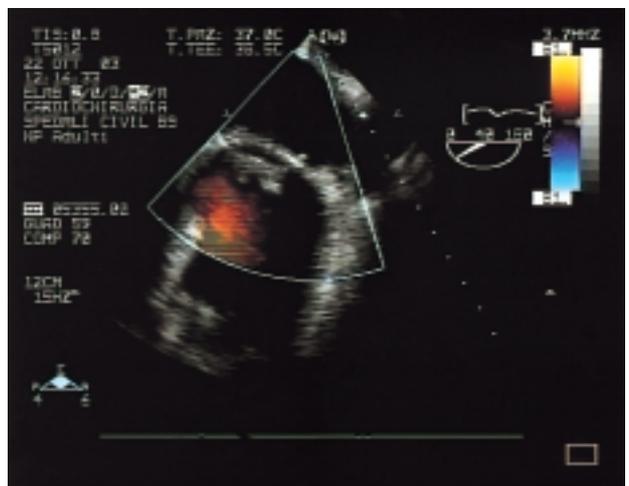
Preoperative transesophageal long-axis view of the prolapsing mitral valve; three regurgitant jets may be seen (postero-medial, central, and antero-lateral).
